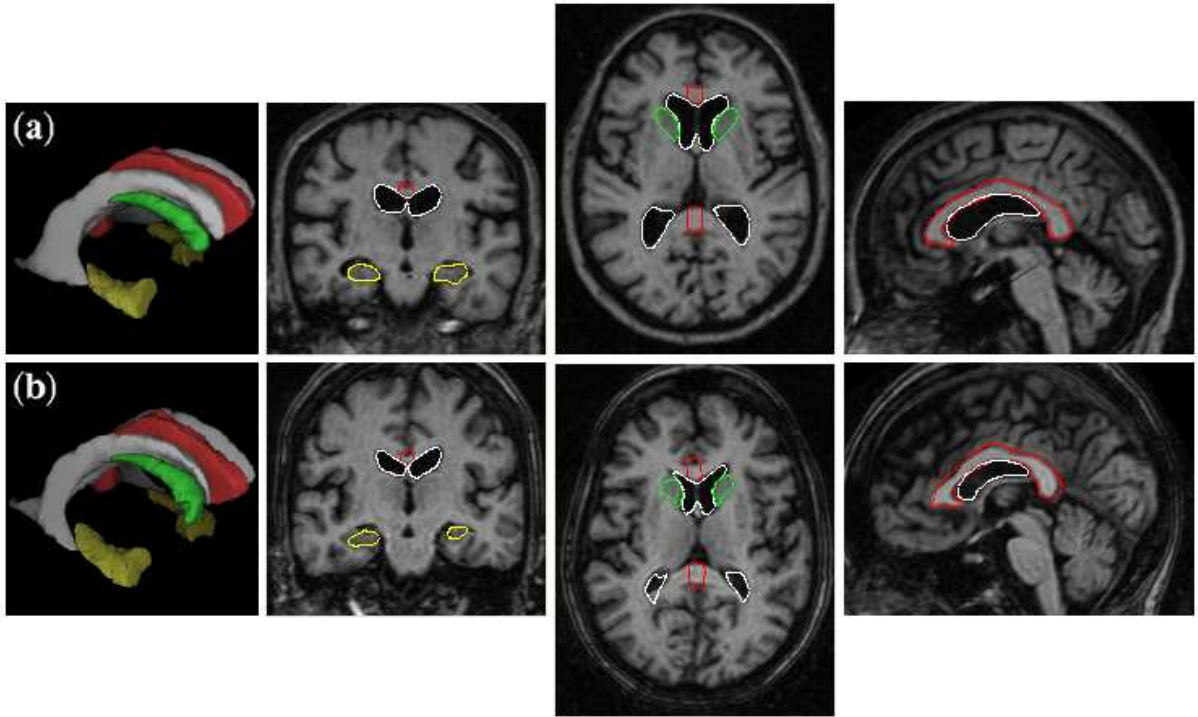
(a) reference MRI with manually delineated structures superimposed (corpus callosum in red, ventricles in white, caudate nuclei in green and hippocampi in yellow); (b) reference MRI registered to an input MRI and initialized structures.
